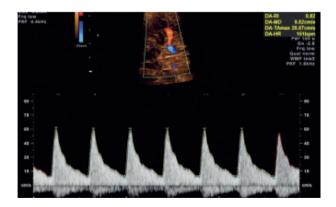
Normal middle cerebral artery Doppler waveform. 12 Reproduced with permission. @ 2013 ISUOG.
